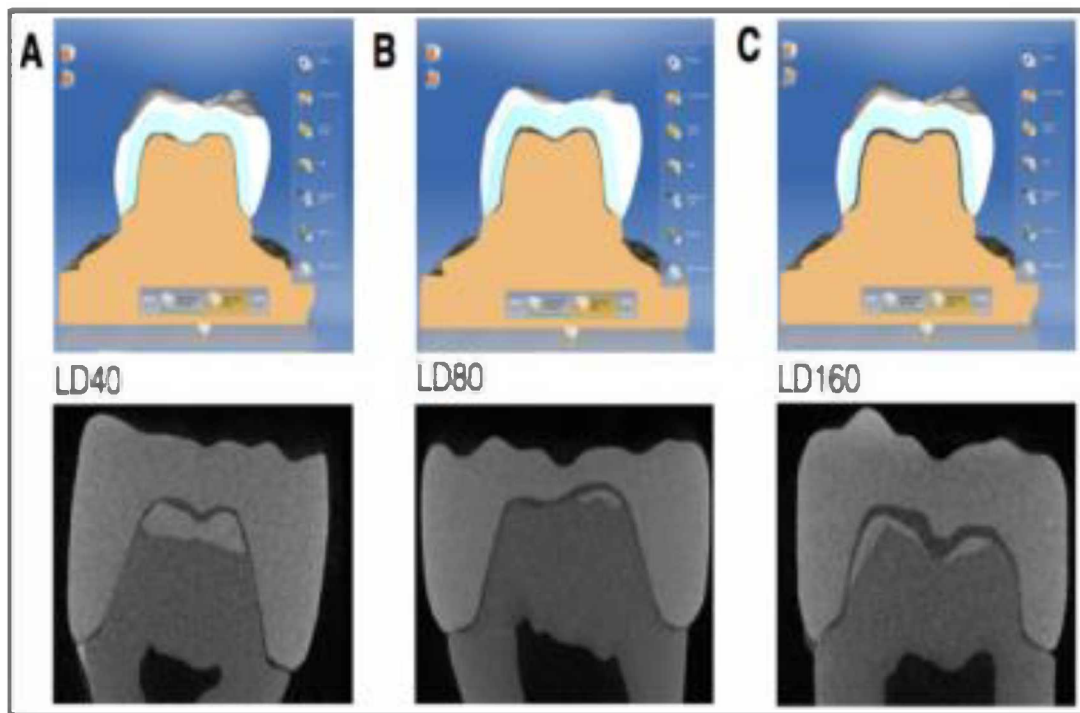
Different luting space settings on CAD/CAM crown design software and micro-computed tomography images: LD40 (A), LD80 (B), LD160 (C).
